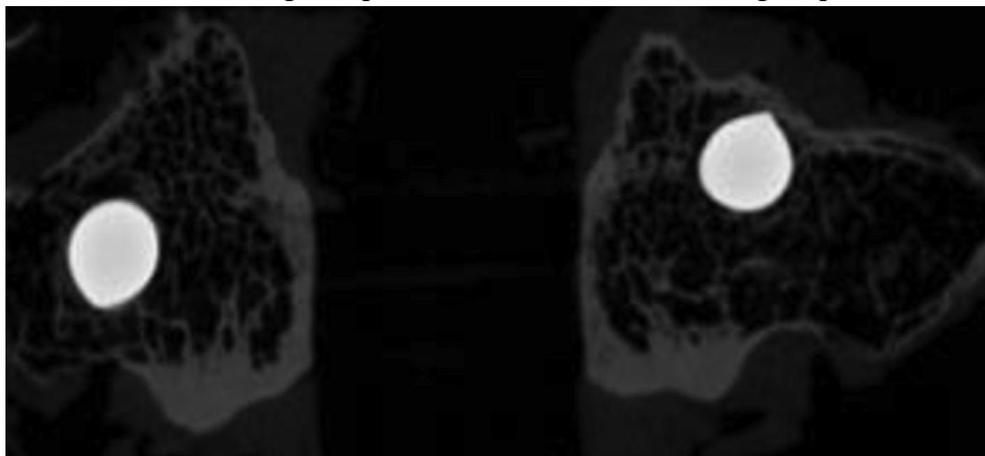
CT image of the pedicles showing the position of a traditional pedicle screw (left) and a superior cortical screw (right) (20).
